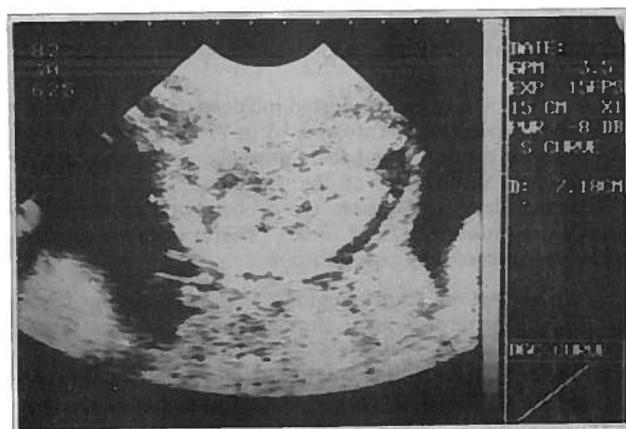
Mass seen at ultrasonography to be attached the placenta (Diasonics 100)
